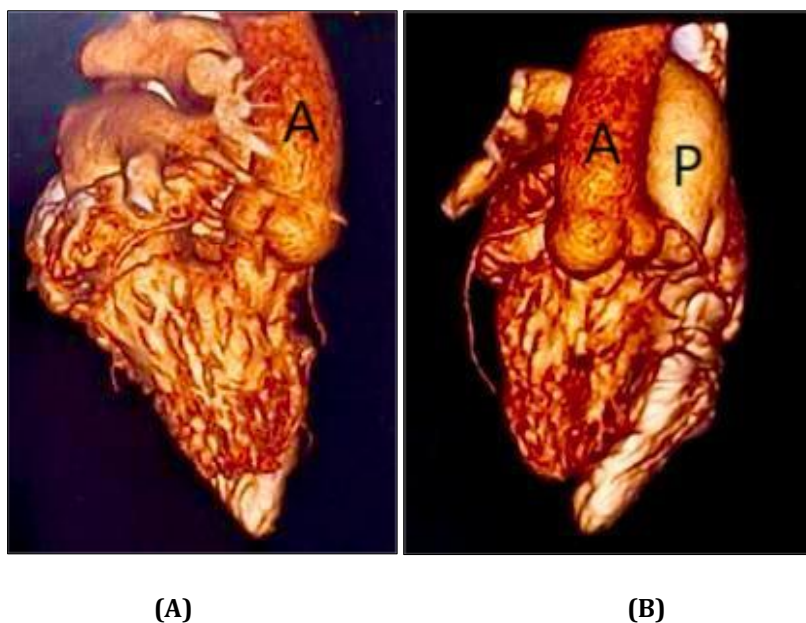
Cardiac CT images. (A) Aorta arising from anterior morphological RV; (B) Aorta arising from anterior morphological RV and Pulmonary artery arising from posterior morphological LV. A; Aorta; P, pulmonary artery
